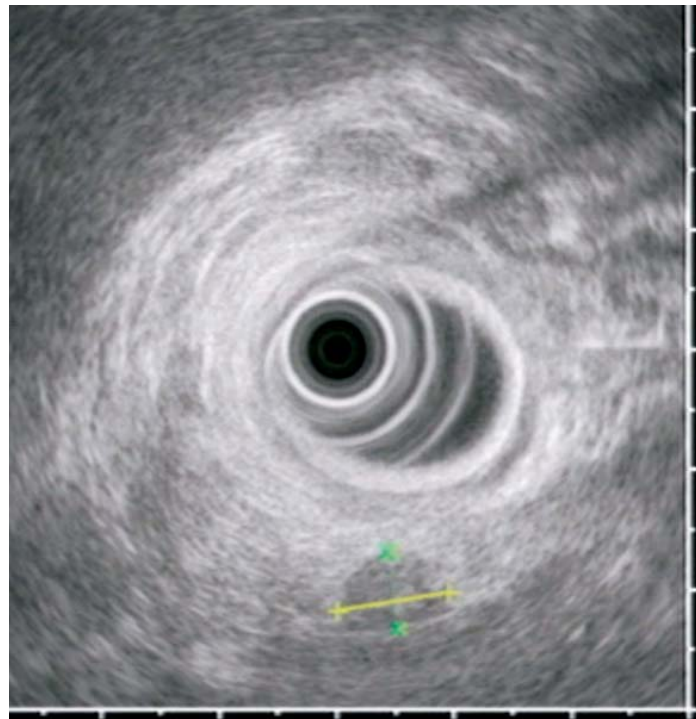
Endoscopic ultrasound image of a small islet cell tumor (marker lines) in the head of the pancreas. (Color version of figure is available online.)
